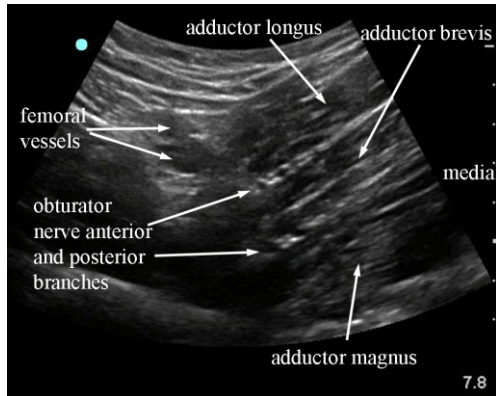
sonogram of transverse scan of proximal thigh from anterior. The two branches of the obturator nerve are apparent either side of adductor brevis.
